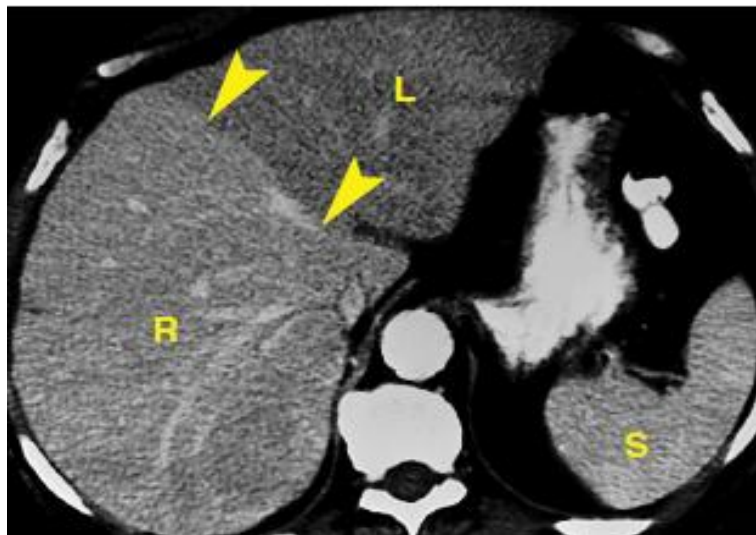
CT image of Focal fatty liver .The left lobe of the liver (L) is lower in density than the right lobe of the liver (R) and the spleen (S). A strikingly sharp boundary (*arrowheads*) separates the left and right lobes. This appearance is characteristic of focal fatty infiltration. (Webb et al, 2014).
